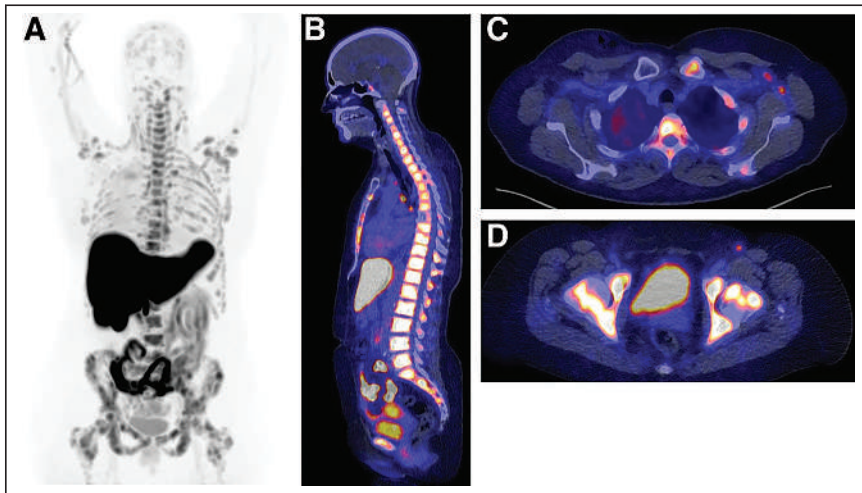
Determination of ER status of disease. In 59-y-old woman diagnosed with ER-positive lobular BC 2 y previously and treated with tamoxifen, ER-positive bone metastases were identified 1 y after initial diagnosis. She was treated with first-line endocrine therapy in palliative setting. Thereafter, disease became progressive and palbociclib was added. However, after 2 wk of treatment, she presented with pancytopenia. ^{18}F -FES PET was performed to determine whether bone metastases were still expressing ER and whether there was a rationale for another line of endocrine therapy. Increased ^{18}F -FES uptake could be seen in lymph nodes above and below diaphragm and in multiple bone lesions (e.g., spine, costae, scapulae, sternum, and pelvis) (A, maximum-intensity-projection image; B, PET/CT sagittal view; C, PET/CT transversal view of left axillary region; D, PET/CT transversal view of pelvic region with positive inguinal lymph node). In addition, bone marrow involvement was visible. Diagnosis was settled on ER-positive metastatic disease, clinical dilemma was solved, and another line of endocrine therapy could be considered. However, because of bone marrow involvement, chemotherapy was indicated to achieve therapeutic effect more rapidly.
